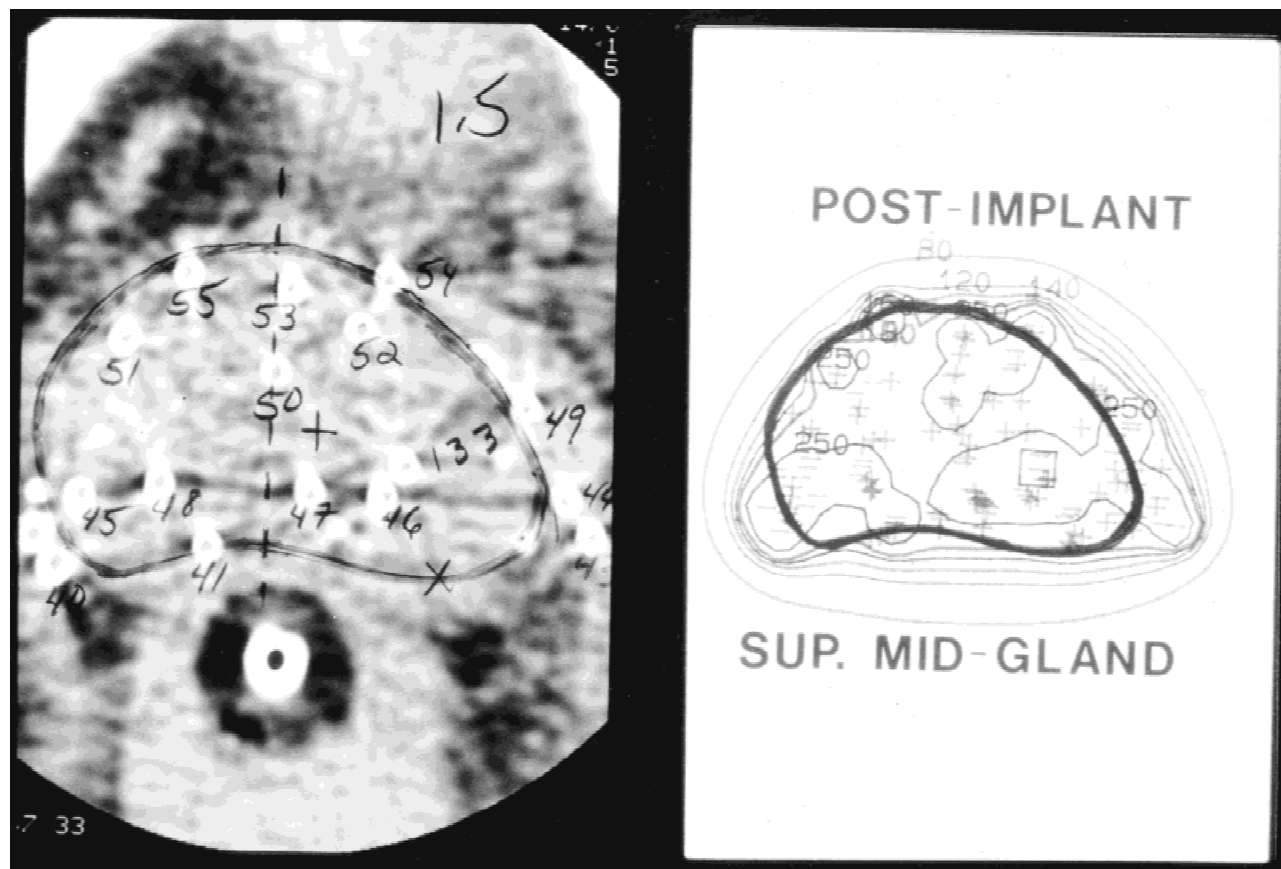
Postimplant conformal planning CT and resulting brachytherapy isodose curves.
